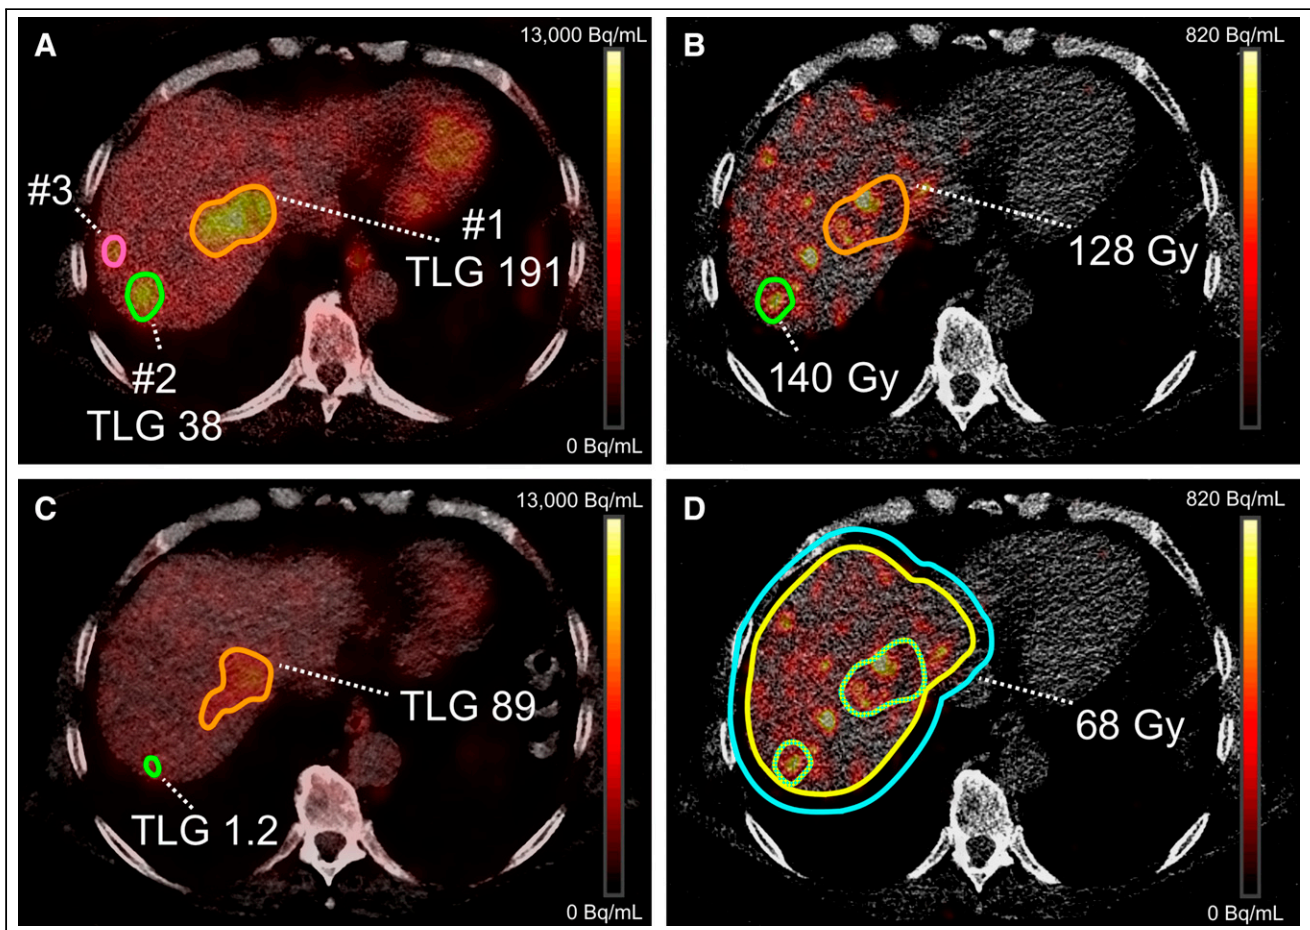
Example of absorbed dose and total lesion glycolysis (TLG) calculation. (A) Threshold-based mask on baseline ^{18}F -FDG PET to delineate 3 lesions and determine baseline TLG; lesion 3 had volume $< 5\text{ cm}^3$ and was excluded. (B) VOIs registered to posttreatment ^{90}Y PET/CT to determine individual tumor-absorbed dose. Dose distribution was more heterogeneous in lesion 1. (C) TLG measurement on 3-mo follow-up ^{18}F -FDG PET. Lesion 2 had decrease in metabolic activity of 96% (PR), whereas lesion 1 had only 53% decrease (PR). (D) Healthy liver–absorbed dose as measured on post-treatment ^{90}Y PET/CT. Liver contour was manually delineated; this VOI was subsequently expanded by 10 mm in all directions to include all hepatic activity. Healthy liver VOI was achieved by subtracting all lesion VOIs.
